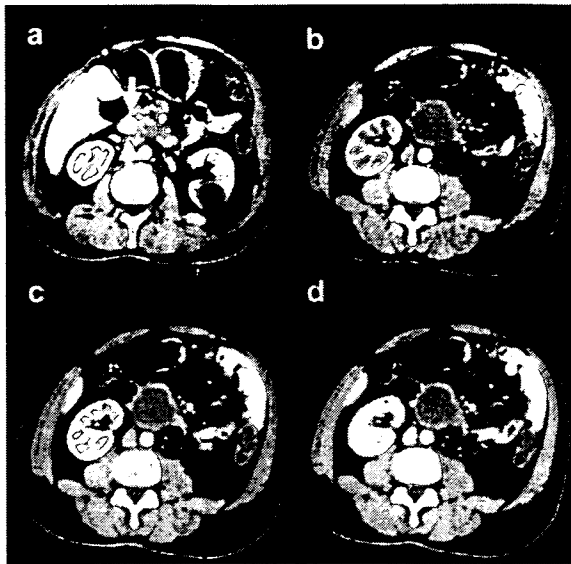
The tumor showed heterogeneous iso- or low signal-intensity on T2-weighted images, and low signal-intensity with marginal enhancement on T1-weighted images after i.v. administration of gadolinium-contrast medium. a. T2-weighted MR image. b. T1-weighted MR image. c-d. Postcontrast T1-weighted MR image.
